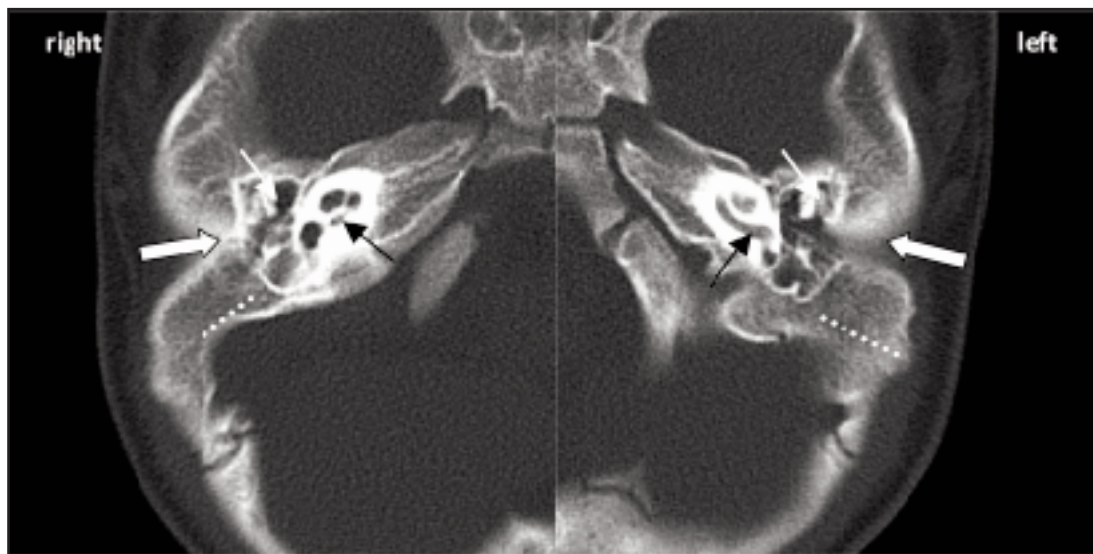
Axial HRCT of the right and left temporal bone depicting bilateral atretic canal (block-arrow) with abnormal ossicles (white arrow), un-pneumatized mastoid (dotted line) and normal cochlea turns (black arrow).
